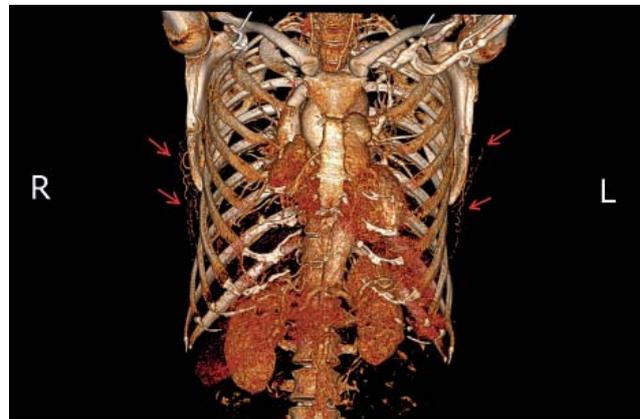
3D reconstruction obtained from the CT scan. Collateral vessels provide an alternative source of blood supply to the upper extremities (red arrows)
